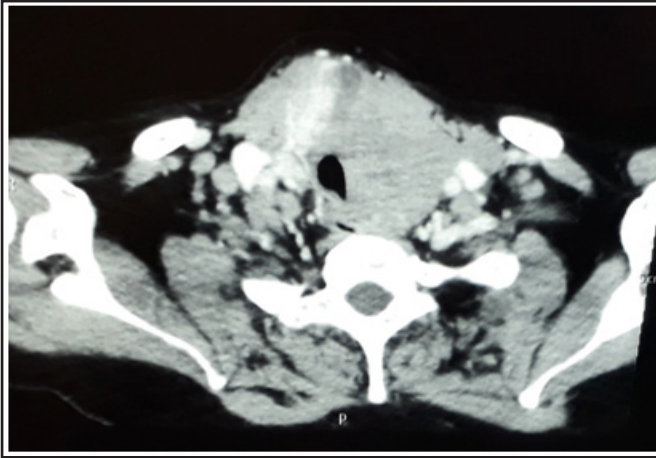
The axial section, contrast enhanced computed tomogram of neck showing a large 10cm X 5.6cm heterogeneously enhancing, solid lesion in left lobe, isthmus, with mild extension into right lobe of thyroid.
